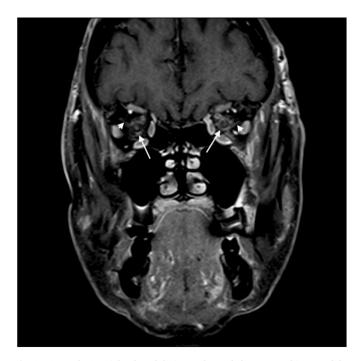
Coronal T1-weighted, gadolinium enhanced, fat-saturated image of the orbits shows bilateral perineural enhancement of the optic nerve sheaths (arrows) and stranding of orbital fat (arrowheads). Image obtained three days after presentation.
